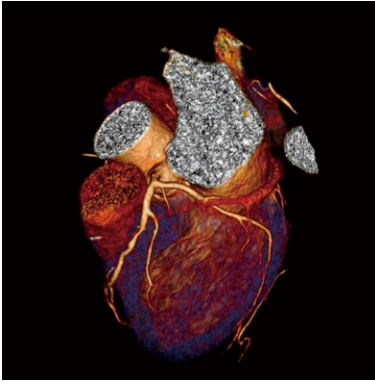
Three-dimensional volume rendering of the left coronary artery is acquired with dual-source computed tomography angiography in a 47-year-old woman suspected of coronary artery disease. Left anterior descending and left circumflex are clearly demonstrated without any sign of lumen stenosis or calcification.
